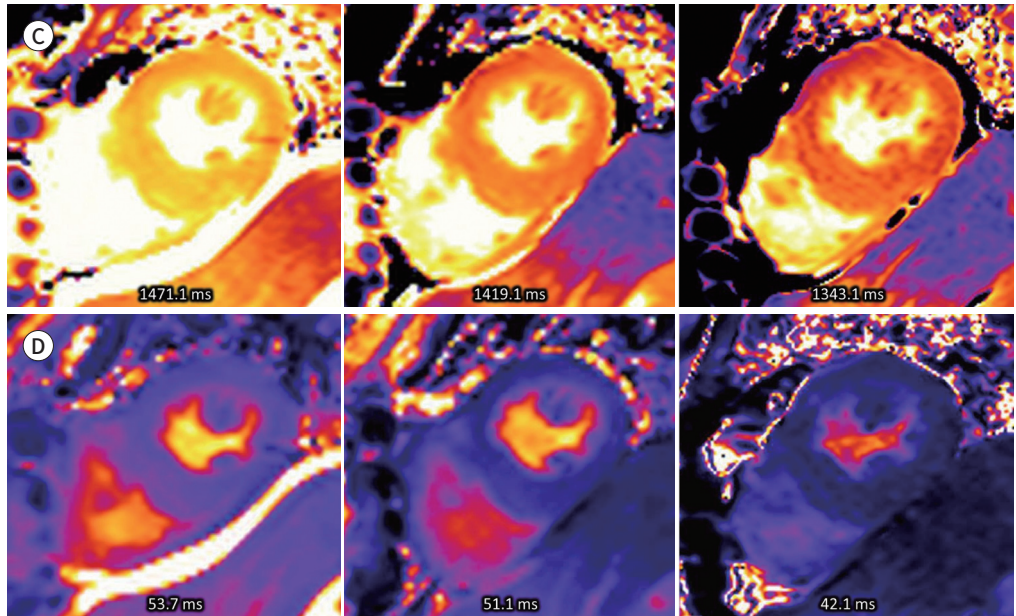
A 59-year-old woman with baseline MRI and 1 month and 12 months follow up MRI after treatment of cardiac amyloidosis.
